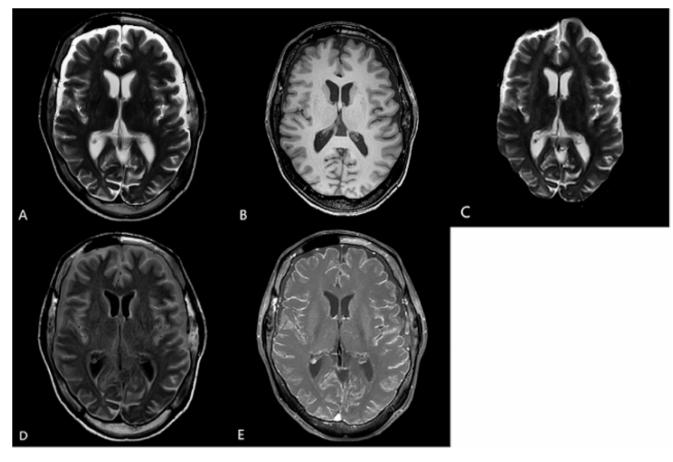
Magnetic resonance imaging (MRI) of atezolizumab- and bevacizumab-induced encephalitis. Axial contrast-enhanced MRI T1 showed diffuse leptomeningeal enhancement in both cerebral cortical
